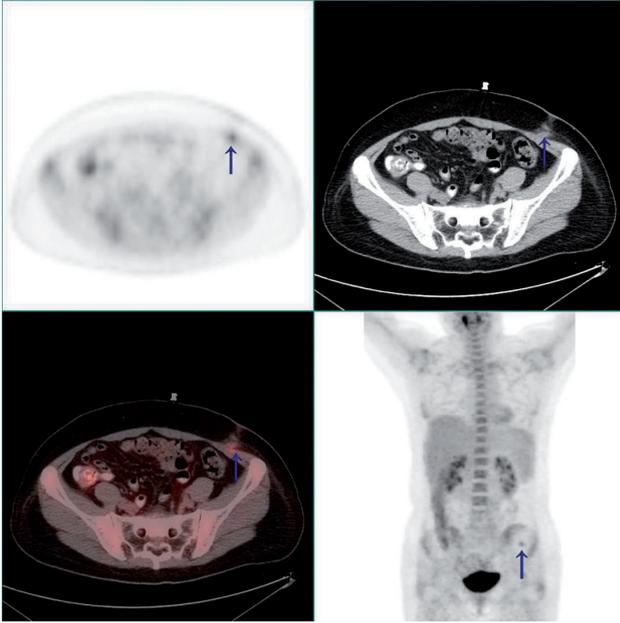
PET-CT showing a hypermetabolic mass in the left lower abdominal wall at the port site. The arrows indicate the hypermetabolic lesion.
